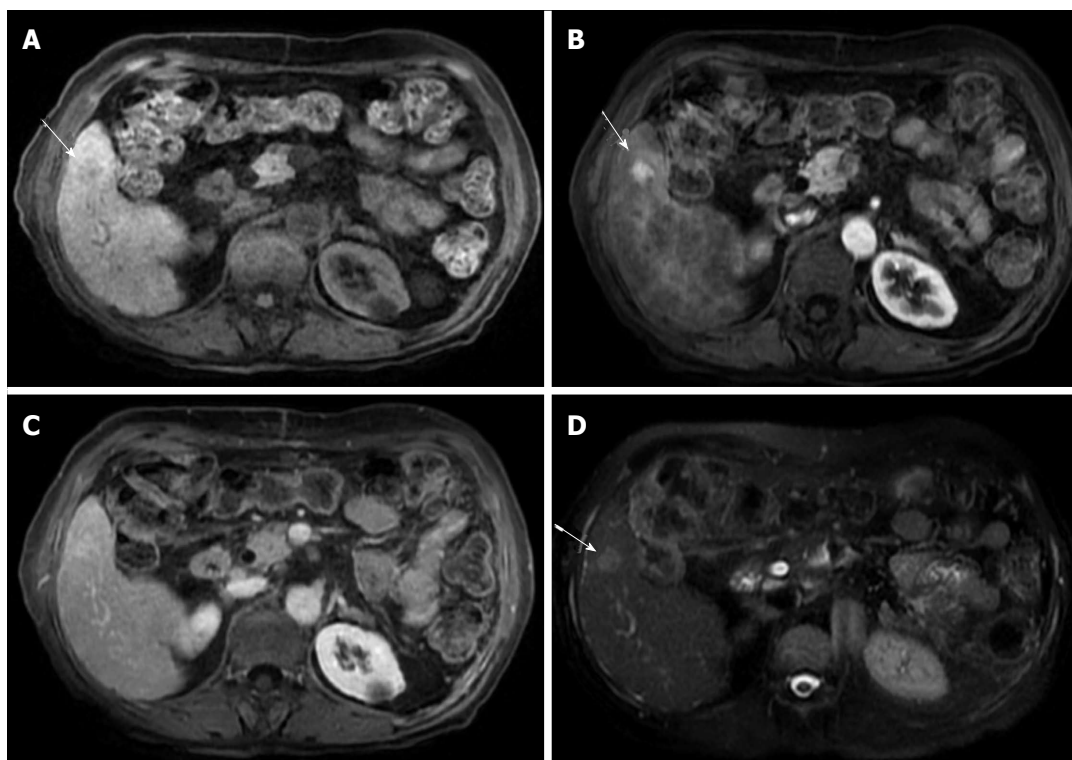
Small, non-washing-out hepatocellular carcinoma. A: Pre- and post-contrast fat-suppressed 3D-GRE T1-weighted images during the late hepatic arterial (B) and delayed phases (C). D: Fat-suppressed SSFSE T2-weighted image. There is a small nodule at hepatic segment #5, which demonstrates minimally decreased T1 signal on pre-contrast images (arrow, A) and increased arterial enhancement (arrow, B). The nodule demonstrates iso to slightly increased signal on the delayed phase images, without clear washout (C), but mildly increased T2 signal intensity (arrow, D) in keeping with an HCC. Note that T2 signal alteration increased the accuracy of diagnosing HCC in this patient, despite the lack of delayed washout (also see Figure 17). HCC: Hepatocellular carcinoma; GRE: Gradient recalled echo; SSFSE: Single-shot fast spin-echo.
